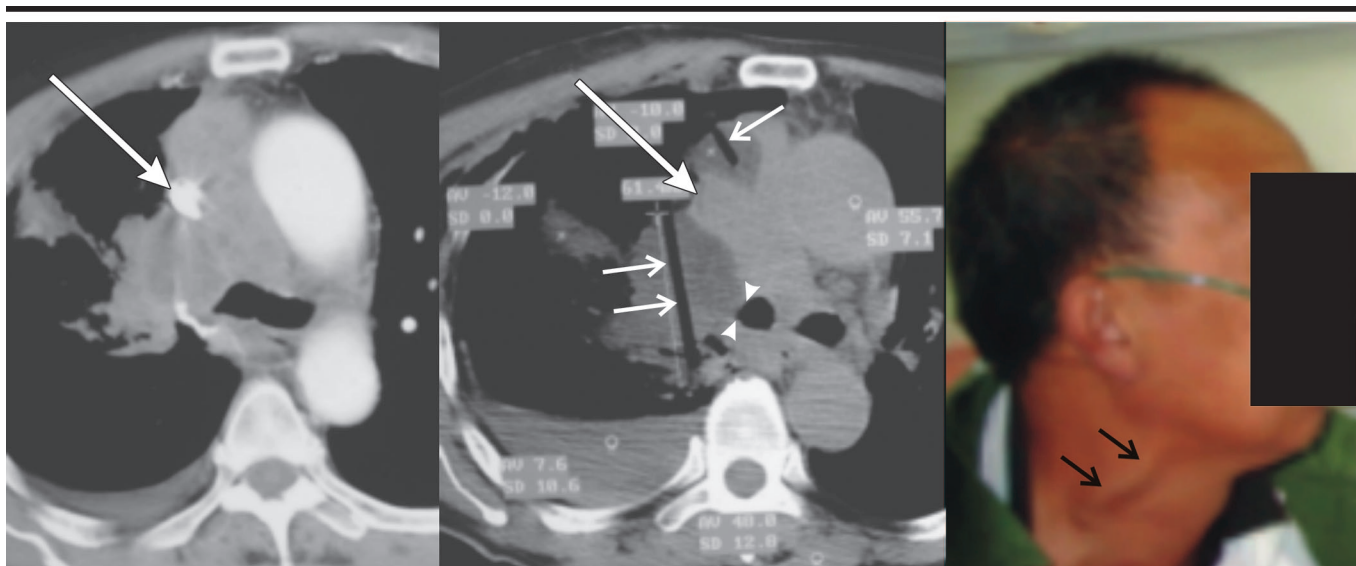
Transverse CT images obtained during cryotherapy for treatment of superior vena cava syndrome with use of multiple cryoprobes and during short-term clinical follow-up in patient who presented with facial edema and prominent jugular venous distention. Because of the lack of readily available emergent radiation therapy in China, this patient was treated for symptomatic relief via the immediate (2–3-day) cryotherapeutic “softening” that a tumor undergoes after ablation. Left: Contrast-enhanced image shows the superior vena cava (arrow) being displaced and compressed by bulky mediastinal and right hilar adenopathies. Middle: Nonenhanced image obtained immediately after cryoprobe removal shows the superior vena cava (large arrow) bracketed by low-attenuating ice, with air in the central cryoprobe tracks (small arrows). The low-attenuating ice extended into the right main bronchus (arrowheads) without complications. Right: Photograph of patient 3 days after PCT shows only mildly dilated neck veins (arrows) and resolved facial edema.
